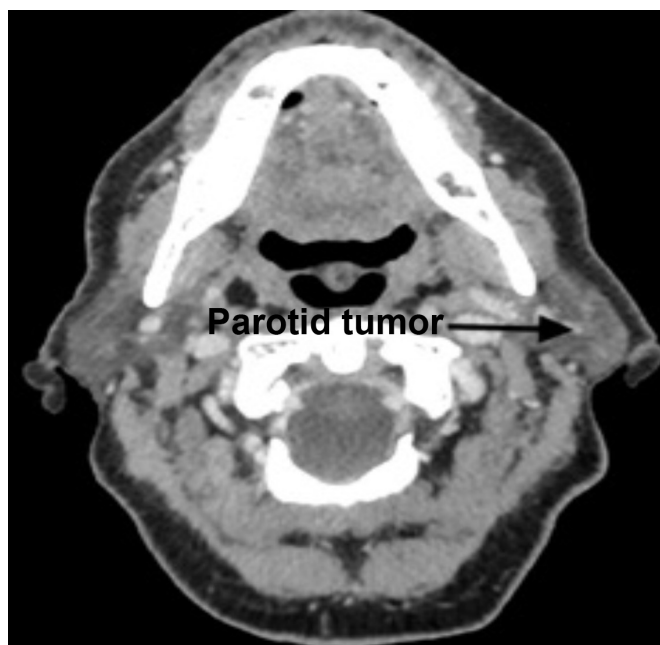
CT scan showing parotid tumour.
